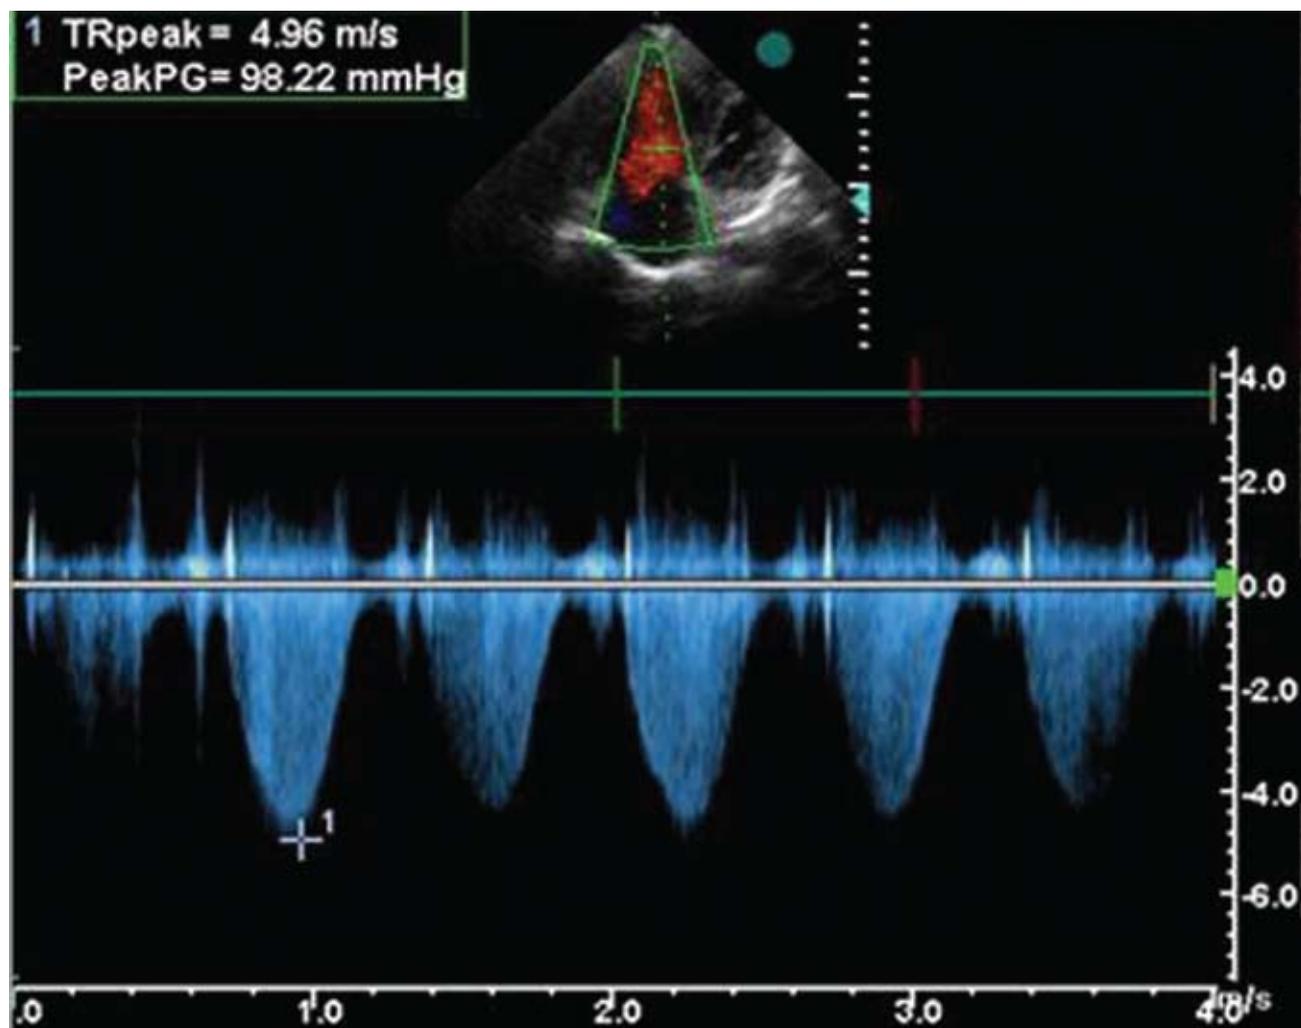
Pulmonary hypertension echocardiographic demonstration.
